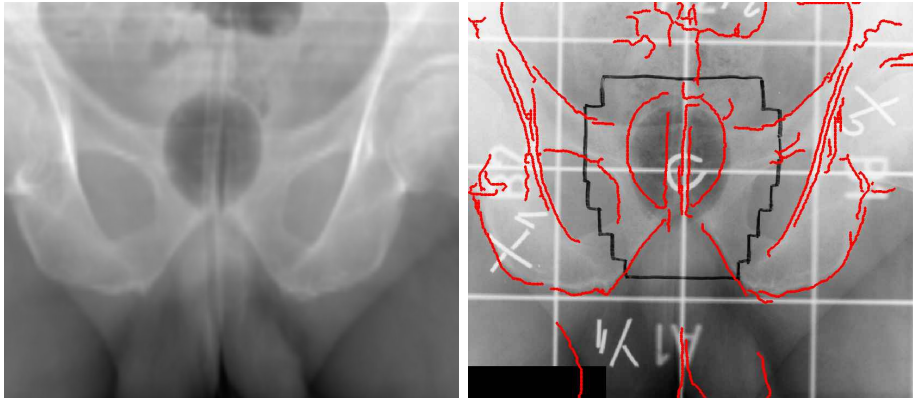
DRR image registered with VGR, X-Ray image with edges from DRR
